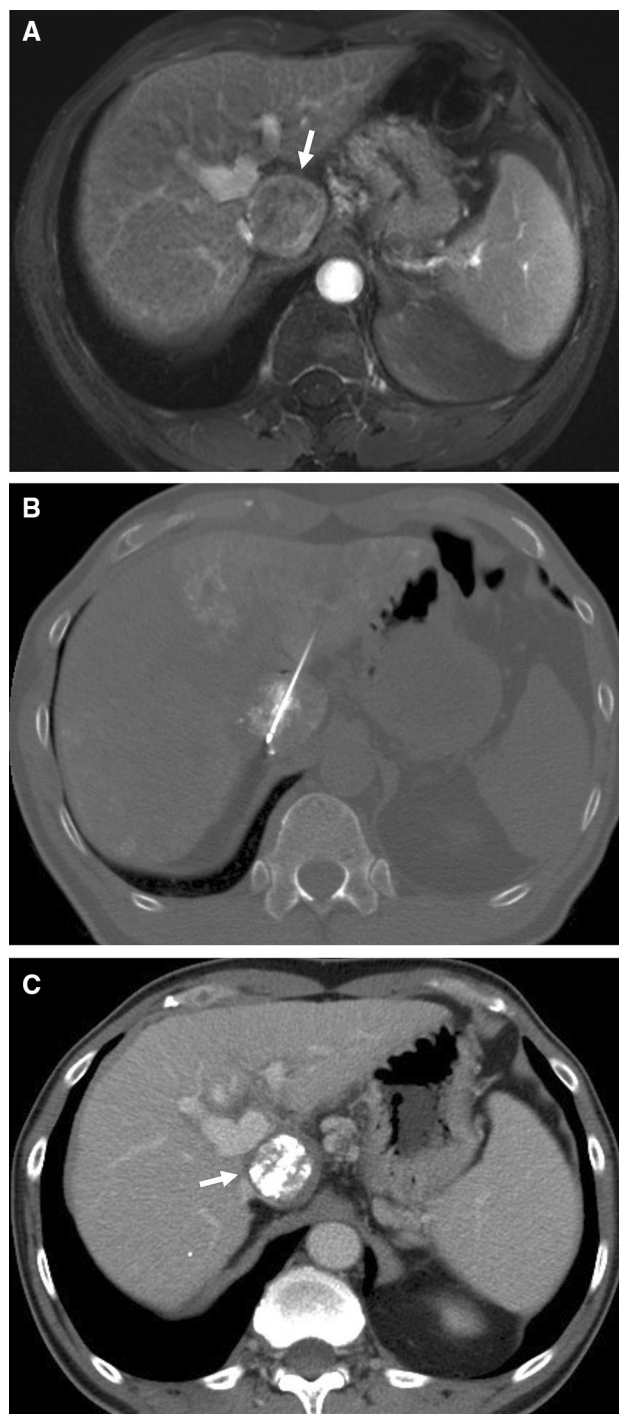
A 58-year-old male with HBV-related liver cirrhosis and abnormal screening ultrasound. A T1-weighted arterial phase MRI of the abdomen demonstrated a 3.3-cm HCC (white arrow) in the Spiegel lobe of segment I with delayed washout (not shown). B CT-guided RFA was performed via anterior epigastric approach. C CT of the abdomen after 6 months revealed complete ablation of the caudate HCC (white arrow), and this patient has remained free of recurrence for 6 years
